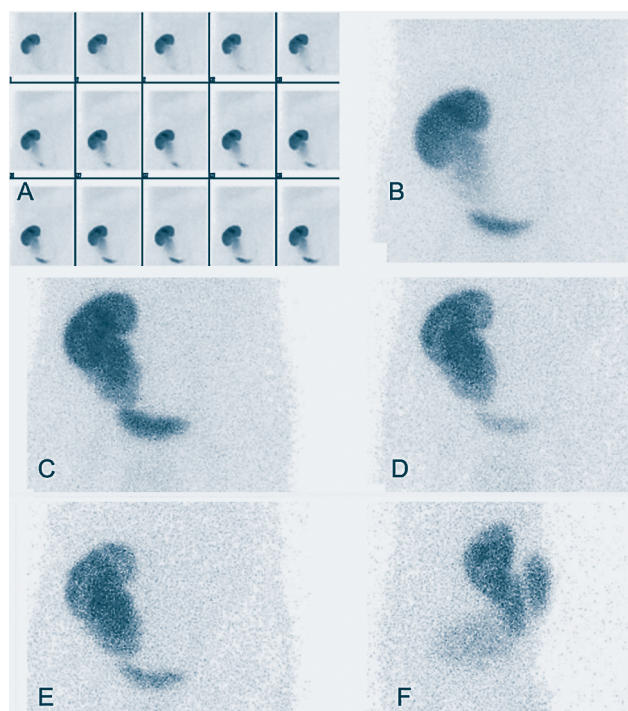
Renal scintigraphy performed with $^{99m}\text{Tc-EC}$. Dynamic anterior images (A) show mild hydronephrosis of the renal graft. The delayed anterior images (B-E) show a dilated pyelocalyceal system and collection of tracer in and around the dilated pelvis. The lateral image (F) shows a subcutaneous tracer collection anterior to the renal pelvis.
